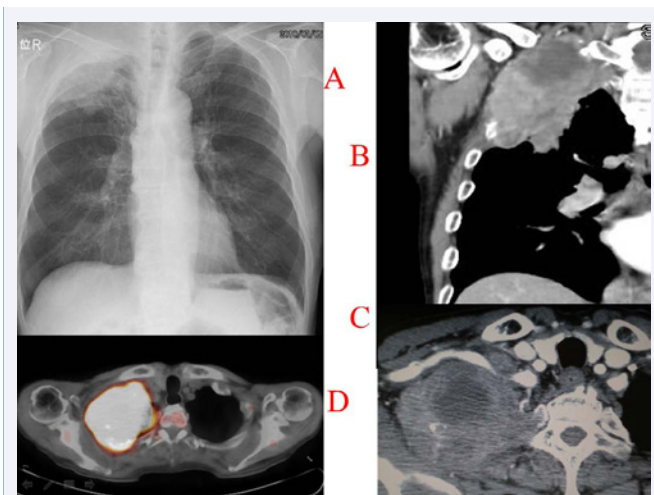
(A) The plain chest radiograph shows a mass in the right upper lung field and dissolution of the first to third ribs. (B, C) The chest CT show a mass 10 cm over the apex of the right lung. They indicate that the mass has invaded the subclavian vessels and three ribs (ribs 1st-3rd) as well as the transverse process at the Th2 level. (D) The FDG-PET image indicates that the tumoral SUV_{max} is 15.09.
